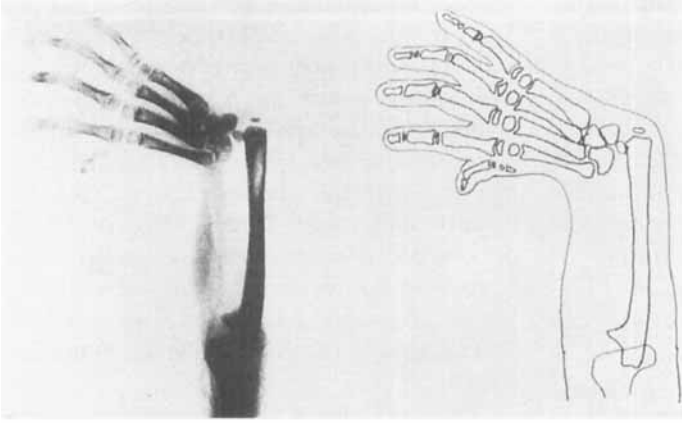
Roentgenogram of the right hand of an 8-year-old girl showing total radius defect, floating thumb and a most severe anomaly of the carpal bones, i.e., defect of the trapezium and scaphoid and fusion between the capitate and trapezoid.
